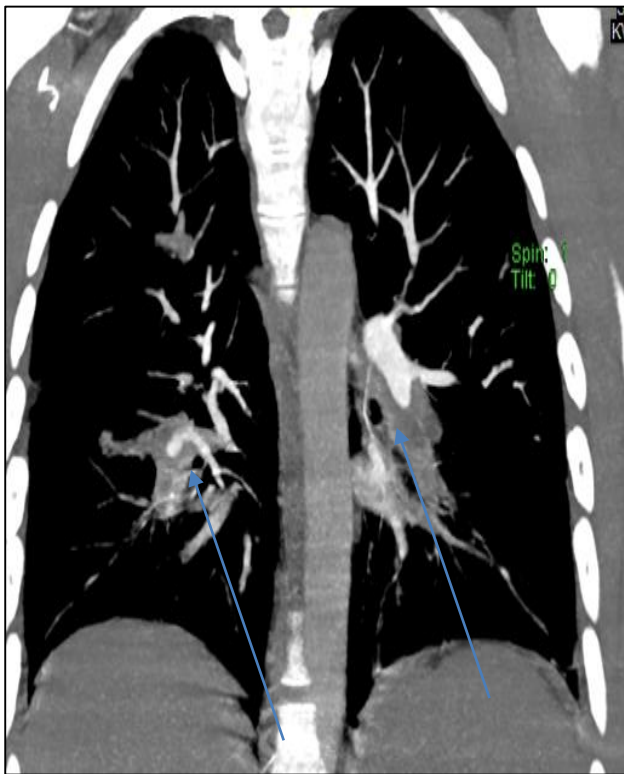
CT angiogram of the chest showing bilateral PE.
